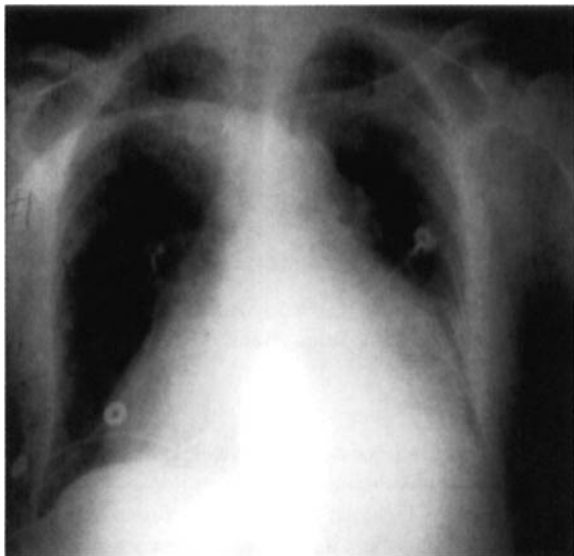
Chest x-ray showing "giant left atrium," horizontal left main bronchus, and prominent pulmonary artery.
